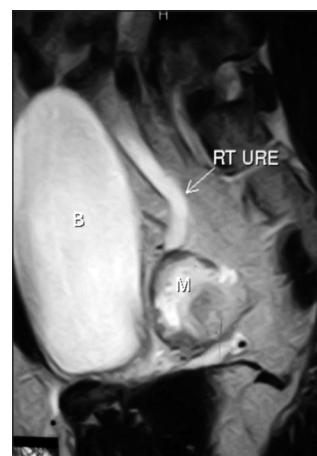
MRI showing the tumor's relationship to the ureter
